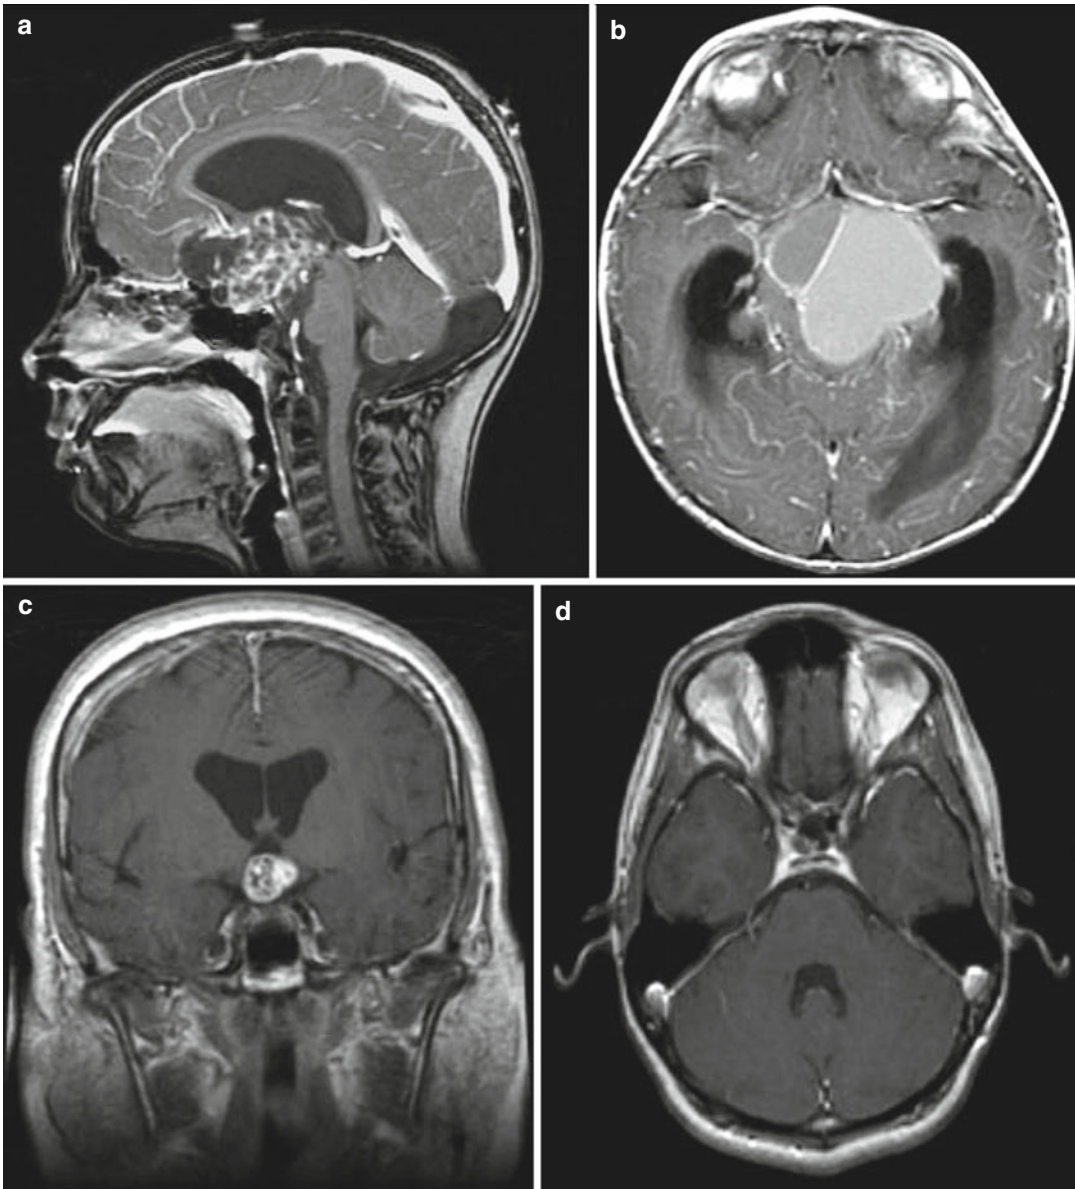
Other examples of craniopharyngiomas: (a) Sagittal T1-weighted image with contrast showing a large mixed solid and cystic craniopharyngioma. (b) Axial T1-weighted image with contrast showing a large cystic craniopharyngioma with two major compartments. (c)
